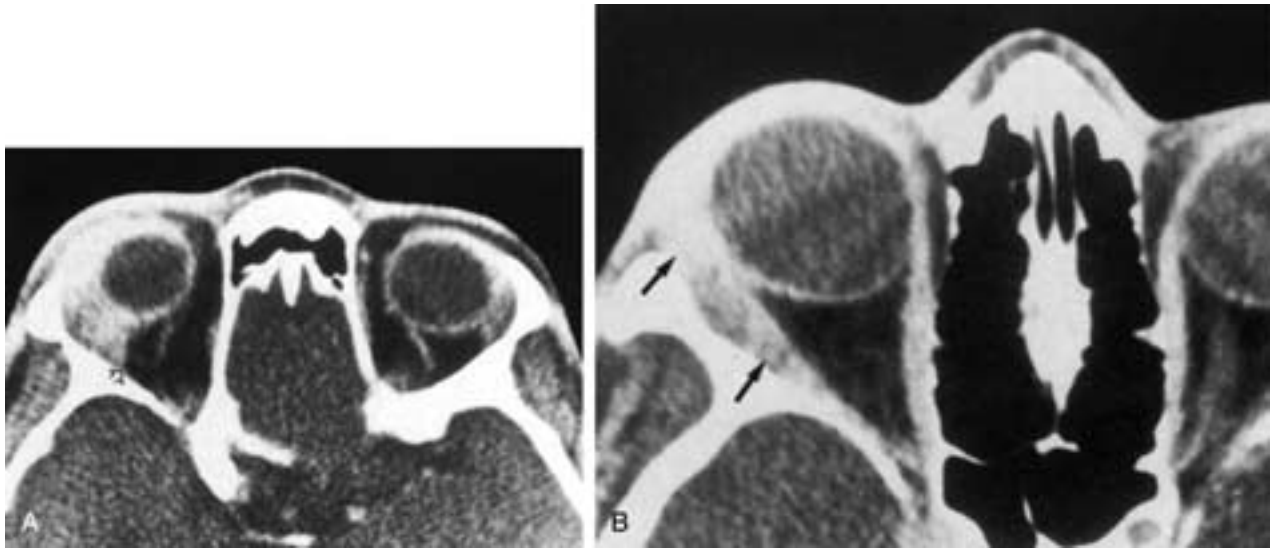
A, Wegener's granulomatosis with involvement of the lacrimal gland. Axial postcontrast CT scan shows diffuse enlargement of the right lacrimal gland. The lesion involves both palpebral and orbital lobes. Notice the rather straight configuration of the posterior aspect of the lesion (*hollow arrow*). In epithelial tumors of the lacrimal gland, the posterior border of the tumor has a rounded configuration. In Wegener's granulomatosis, enlargement of the lacrimal gland may be symmetric and extensive. Notice the slight enlargement of the involved left lacrimal gland in this patient. (From Mafee MF et al. Lacrimal gland and fossa lesions: role of computed tomography. *Radiol Clin North Am* 1987;25:767-779.) B, Wegener's granuloma. Axial CT scan showing an infiltrative process involving the right lacrimal gland and extending along the extraorbital space (*arrows*). (From Mafee MF et al. Orbital space-occupying lesions: role of CT and MRI: an analysis of 145 cases. *Radiol Clin North Am* 1987;25:529-559.)
